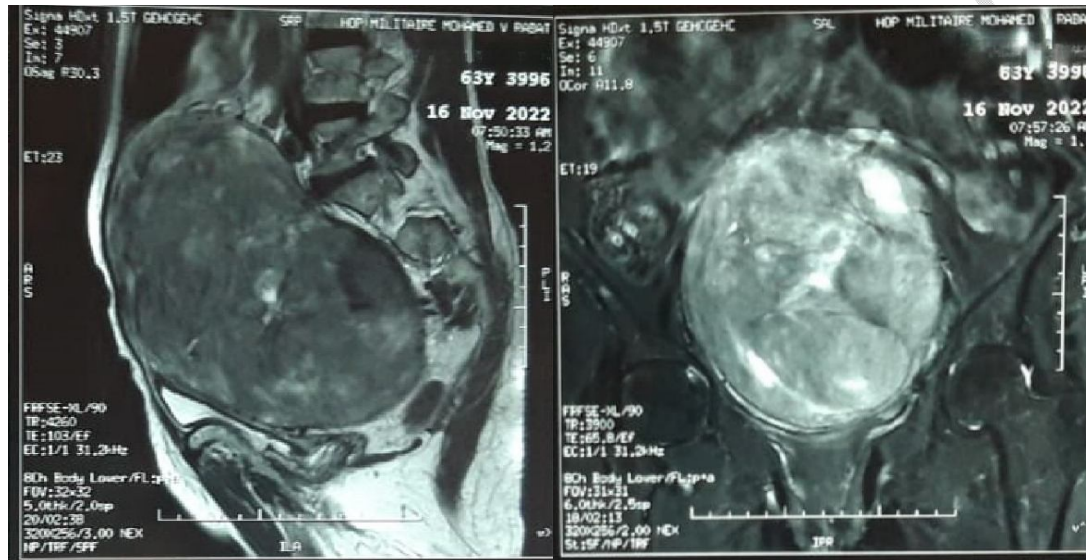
MRI showing a retroperitoneal mass
